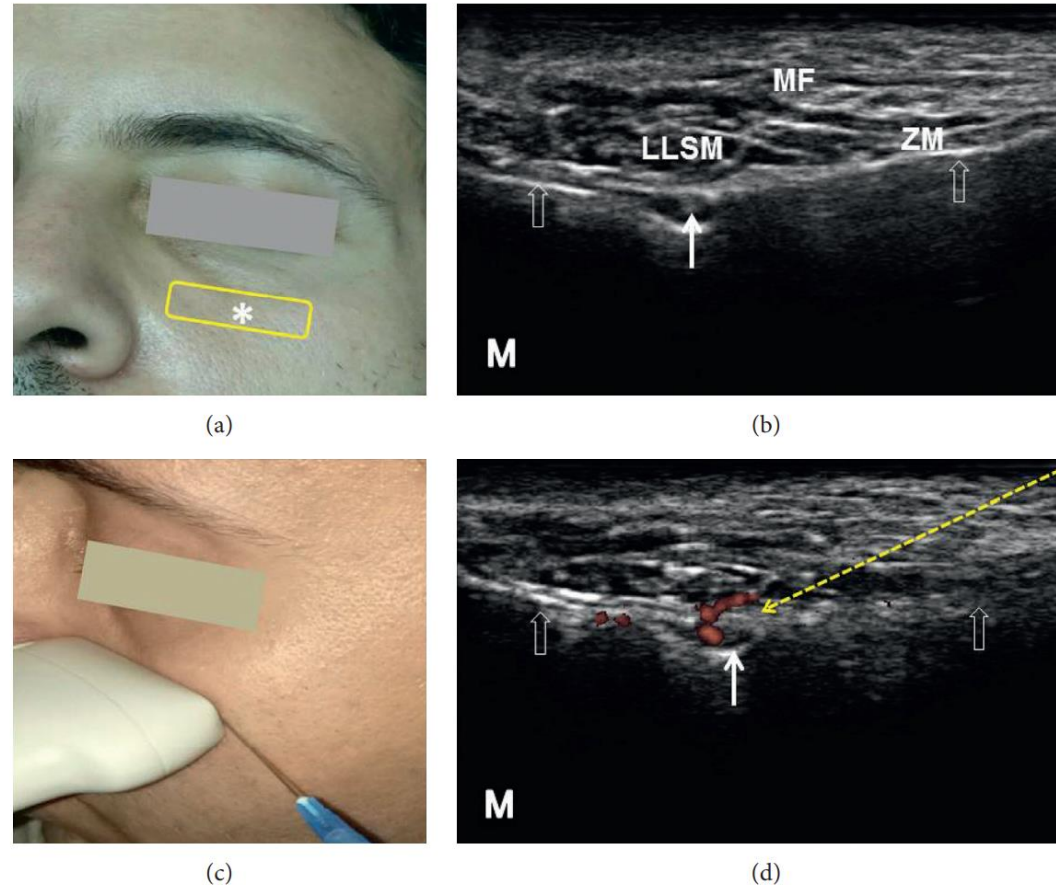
Sonoanatomy and ultrasound-guided injection technique for the infraorbital nerve: (a) the transducer position (yellow rectangle), (b) ultrasound image of the infraorbital nerve (white solid arrow) from the infraorbital foramen, (c) introducing the needle in the lateral-to-medial direction using the in-plane approach to target the infraorbital nerve, and (d) power Doppler image of the infraorbital vessels. The asterisk (*) denotes the infraorbital foramen on the face. The empty white arrows denote the bony cortex of the maxilla. The yellow dashed arrow denotes the needle trajectory. LLSM: levator labii superioris muscle; ZM: zygomaticus minor muscle; MF: malar fat; M: medial side. All the pictures were obtained from the face of the first author.
